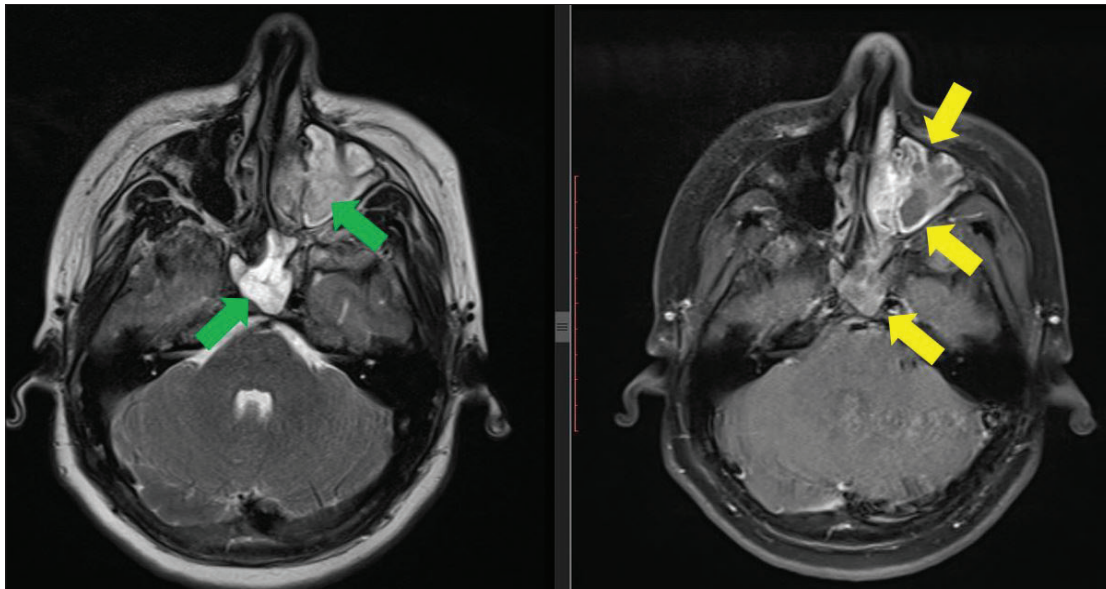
Sections of axial magnetic resonance imaging of T2 weighted and contrast enhanced fat-suppressed T1 from left to right.
